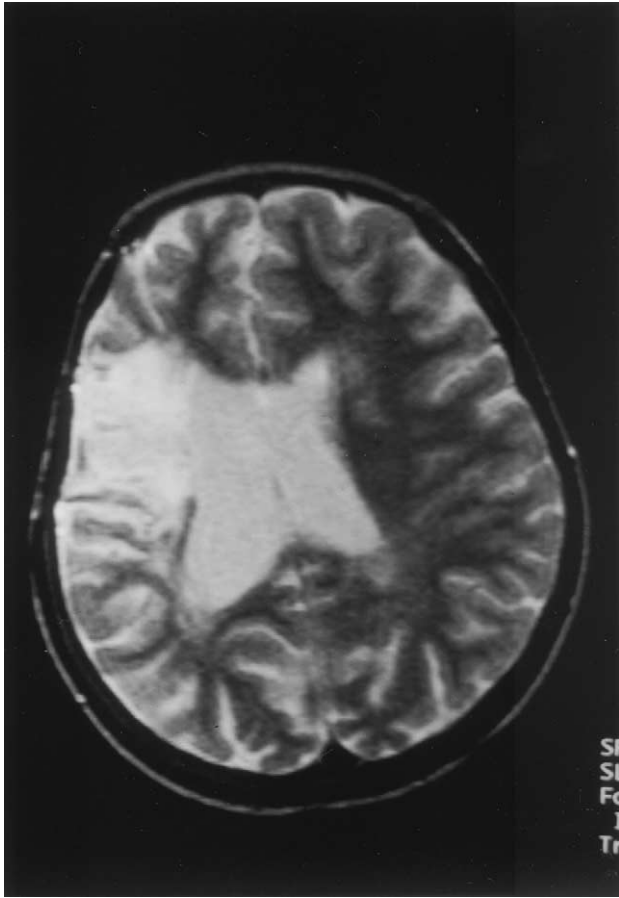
Cerebral magnetic resonance imaging in February 2001 after 5 days of multifocal symptoms demonstrates a right frontotemporal hyperdense area that corresponds with the encephalomalacia scar resulting from the intracerebral bleeding in 1996. There are no signs of active vasculitis. (Siemens open magnetom T₂-weighted sequence.)
